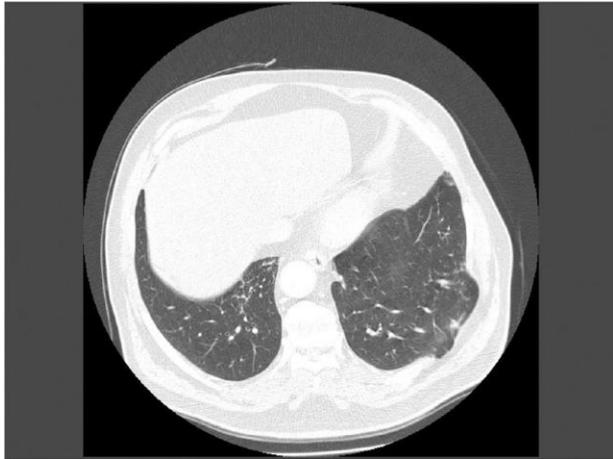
CT scan - cross section of lung hernia
